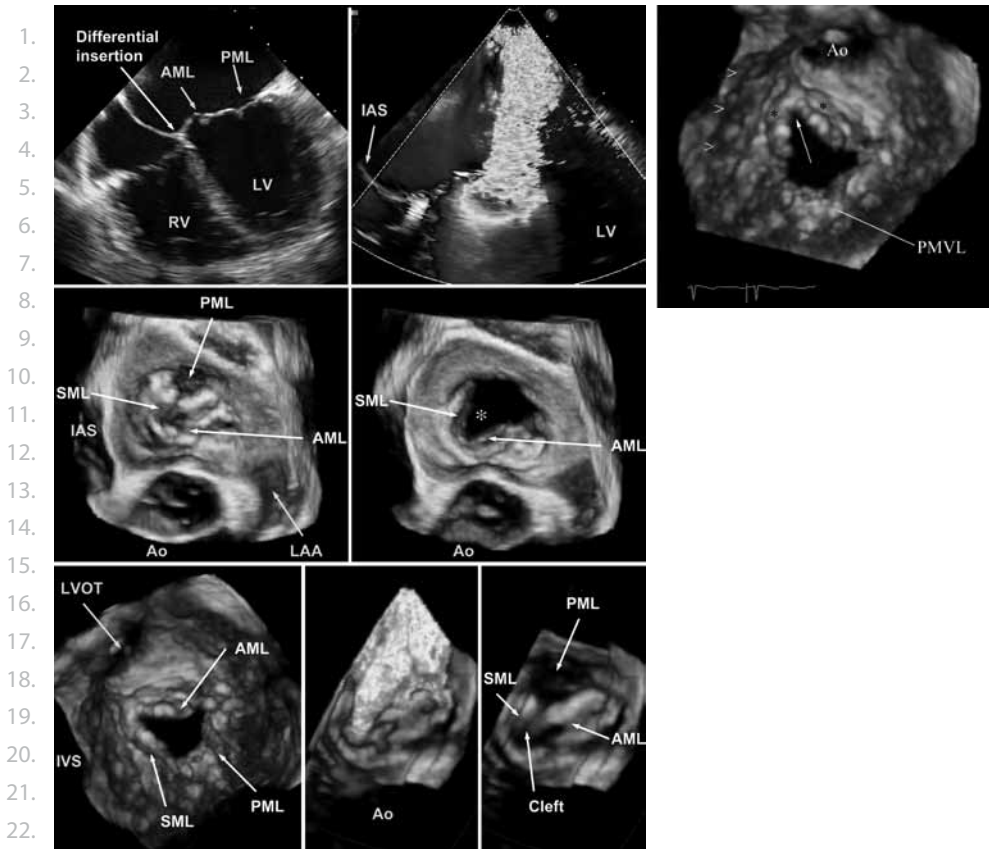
A Transesophageal 2D and RT3DE representation of a true cleft mitral valve with severe regurgitation in a 26-year-old woman. Top left The 2D image clearly depicts differential insertion of atrioventricular valves suggesting a real cleft. The RT3DE en face view from the left atrium to the mitral valve (middle row) shows the prolapsing mitral valve with the cleft (*), a septal (SML), anterior (AML) and posterior mitral leaflet (PML) in systole (middle left) and diastolic opening (middle right). The 3D en face view from the apex to the mitral valve clearly shows the cleft and the chordae attachment to the SML and AML (bottom left). The 3D en face view from the left atrium towards the cleft MV with color Doppler (bottom middle) and without color Doppler (bottom right) clearly depicts the anatomy of the regurgitant lesion. B Magnified view of the true cleft in the anterior leaflet of the mitral valve (arrow). Note that the cleft is orientated toward the aorta and does not extend to the ventricular septum (>). The posterior mitral valve leaflet (PMVL) is indicated. The asterisks (*) mark the two parts of the cleft anterior mitral valve leaflet. RV right ventricle, LV left ventricle, IAS interatrial septum, Ao aortic root, LAA left atrial appendage, LVOT left ventricular outflow tract.
